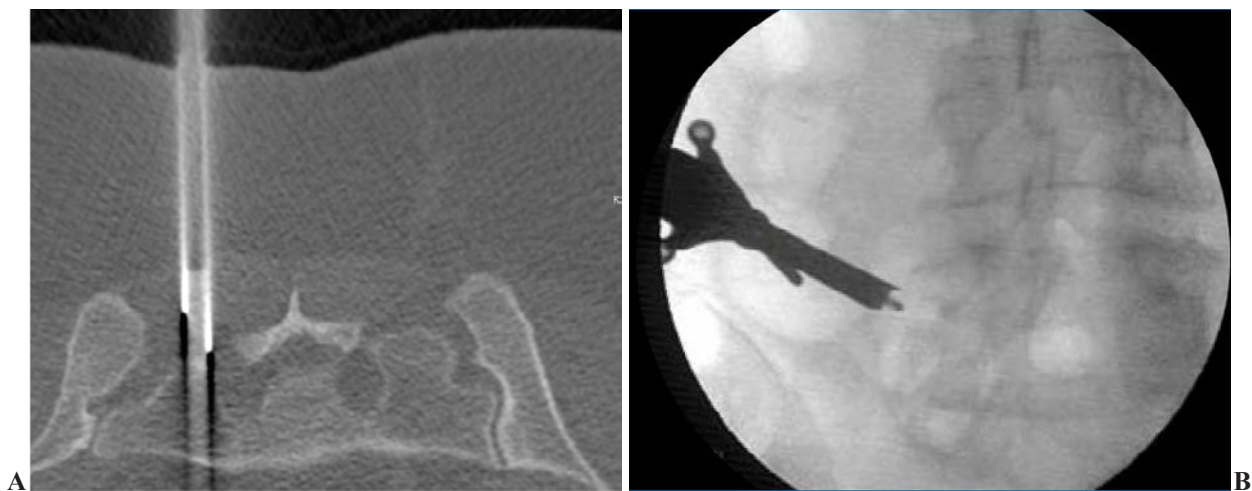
Endoscopic radioablation of the SIJ. Under CT-guidance, a working cannula is placed at the lateral margin of the posterior first sacral foramen (4a) and a RF probe is then inserted into, emerging at the level of the sacral bone (4b), performing strong ablation of the SIJ nerve network at the emerging area.
